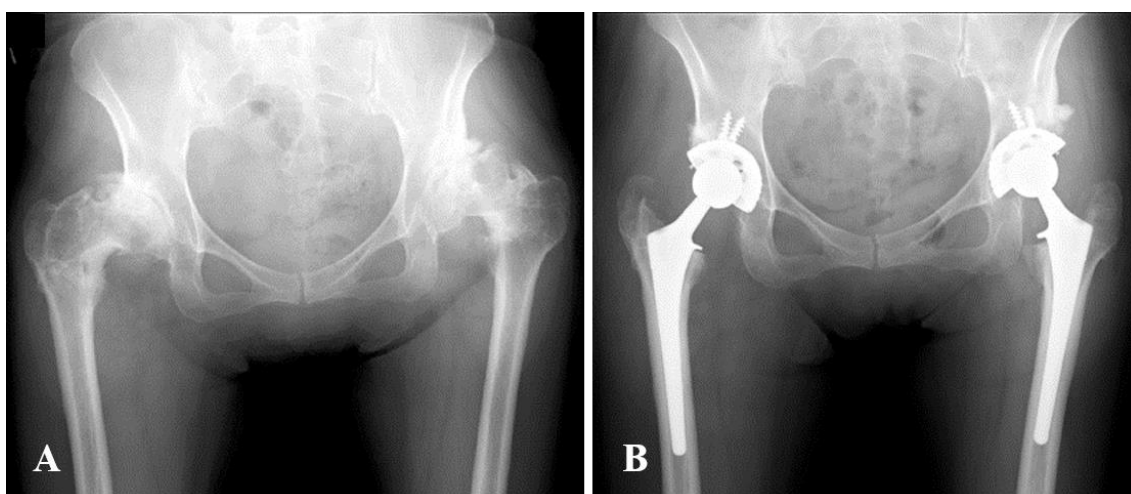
Pre- and postoperative radiographs of the bilateral hip joint of a 53-year-old woman. (A) After failed bilateral curved varus osteotomy of the bilateral femur. (B) Eighty-one months after total hip arthroplasty.
